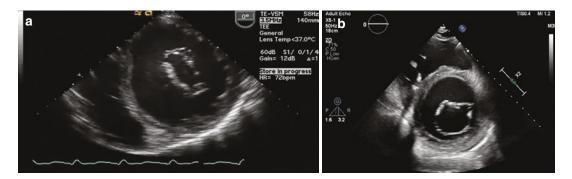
(a) Transgastric basal short-axis view demonstrating the mitral valve opening. (b) Parasternal basal short-axis view demonstrating the mitral valve opening
